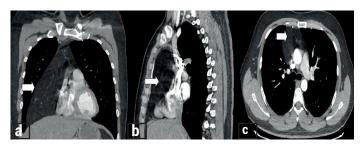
Contrast enhanced CT in coronal (a), sagittal (b) and axial (c) planes show a well circumscribed mass lesion localized in the anterior mediastinum without any invasion
